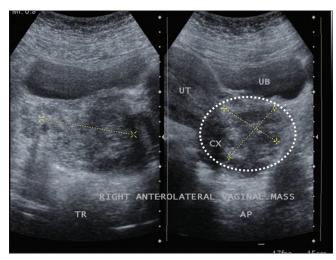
Sonographic image of the vaginal mass (marked by dotted circle) measuring 4.2 cm × 6.5 cm × 4.5 cm after the first cycle of EMACO, EMACO: Etoposide, methotrexate, actinomycin D, cyclophosphamide, and vincristine
